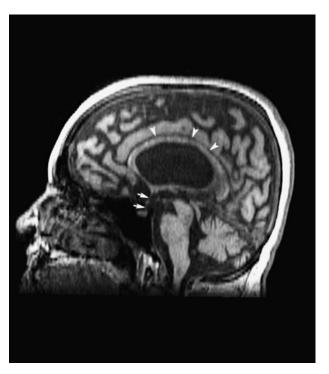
MRI T1 3D FSPGR sagittal image revealing thinning of the corpus callosum (arrowheads) and pituitary stalk hypoplasia (arrows).
